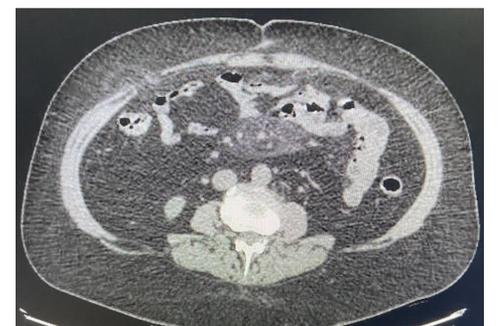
CT-scan previous to TAPP repair
